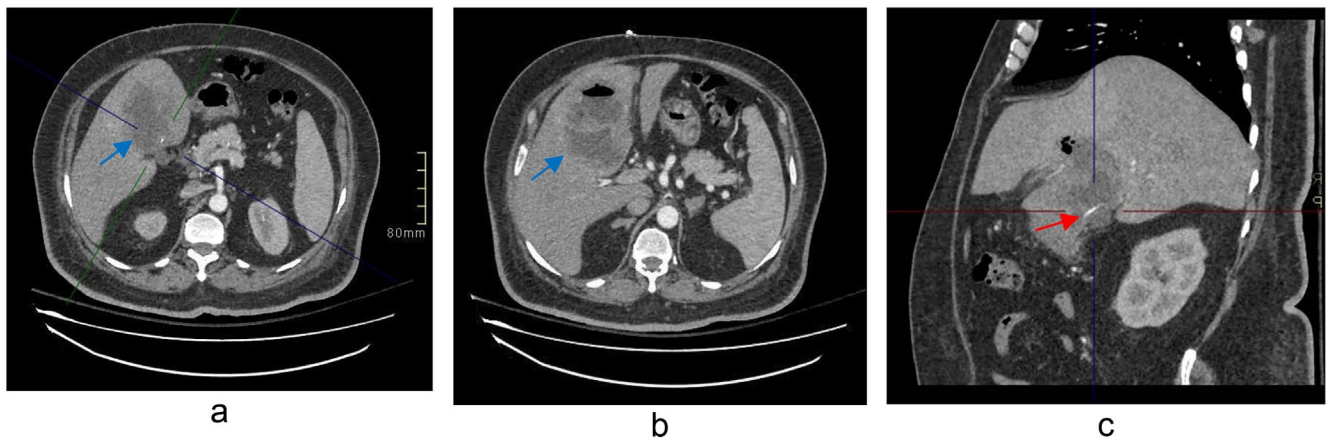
Enhanced computed tomography images. Axial (a, b) and sagittal (c) images showed a large, ill-defined hypodense lesion (blue arrow) in the right lobe of liver along with a linear hyperdense structure, fish bone (red arrow).
